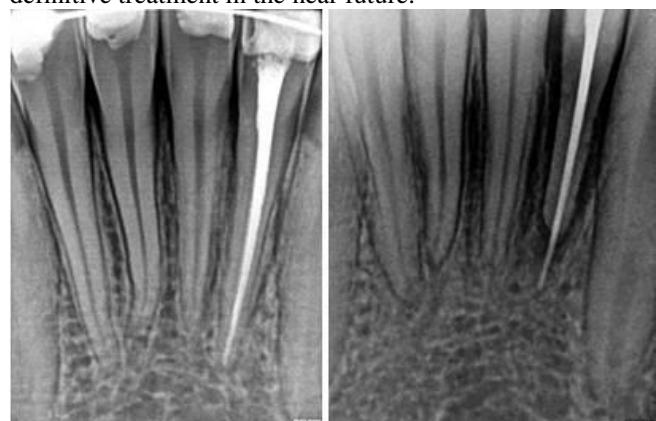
Post-operative view; 1 b: Two dimension radiographic view shows replacement resorption only in mesio-distal aspect.
